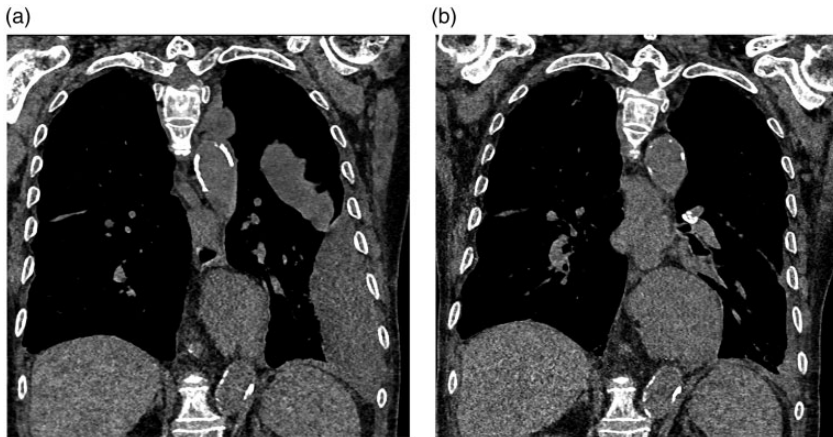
(a) Coronal reconstruction image of chest computed tomographic (CT) images showing left encapsulated pleural effusion and interlobular effusion (b) CT image showing that the pleural effusion resolved without new-onset pleural effusion 3 months after effusion drainage and discontinuation of rivaroxaban.
